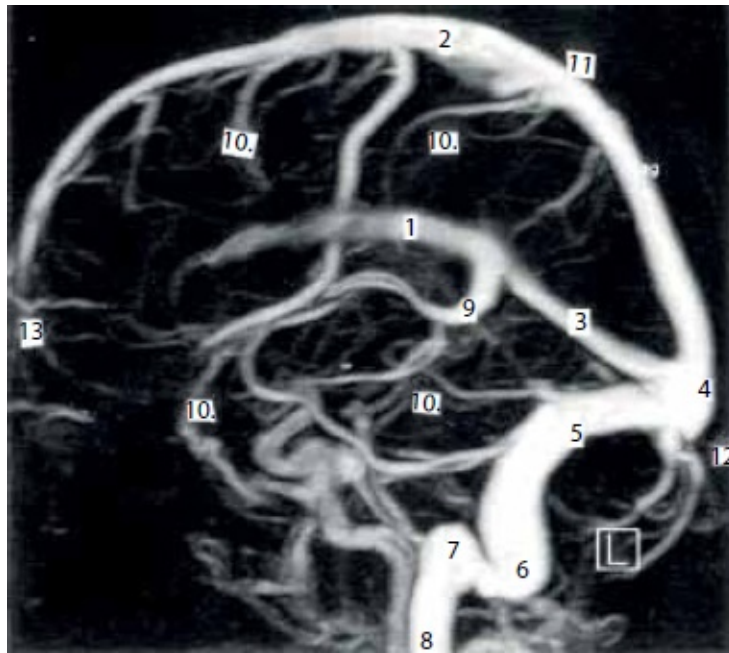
Dural venous sinuses. MRI.
